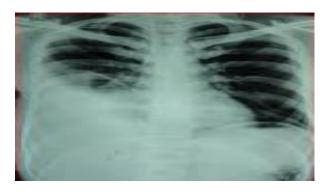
Pre-operative X-ray of right sided multiloculated pleural effusion.
